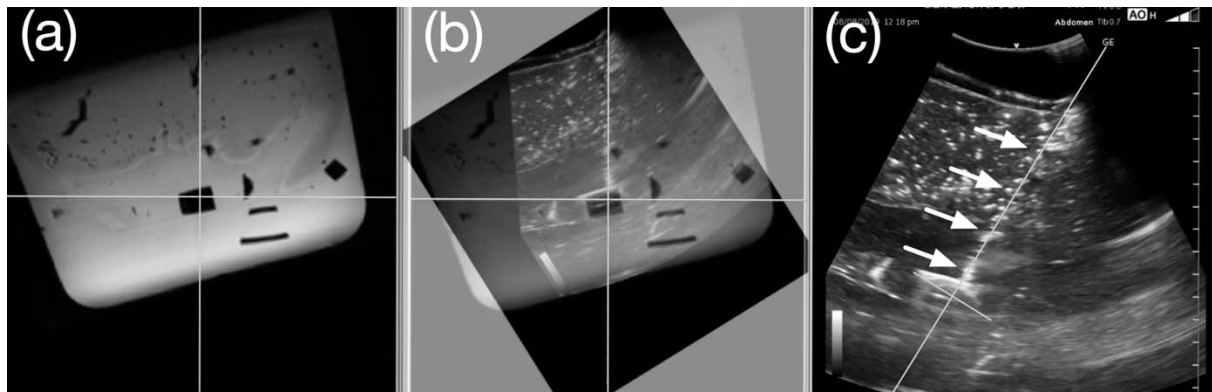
Typical guiding image screenshots: (a) in-plane-90 planning MRI image, where the solid vertical line represents the planned needle path, and its intersection with the solid horizontal line represents the target location; (b) ultrasound (US) image plane fused with in-plane-90 image; (c) US image plane with inserted needle, where the long solid line represents the planned needle path, the intersection with the short solid line represents the target location, and solid arrows indicate the inserted needle.
